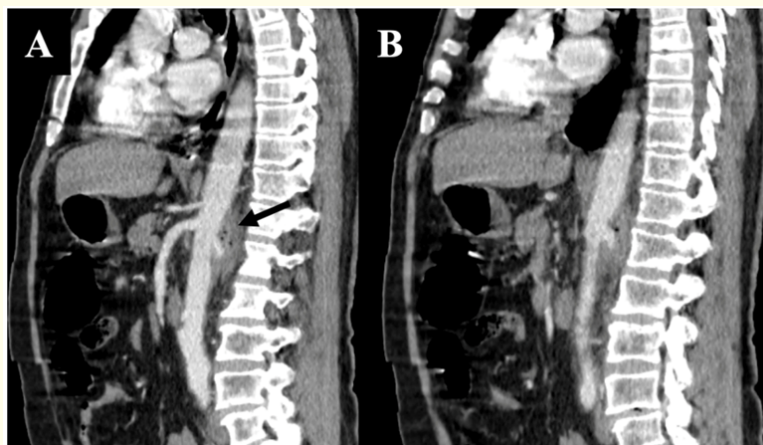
Sagittal reformatted abdominal CT images.
